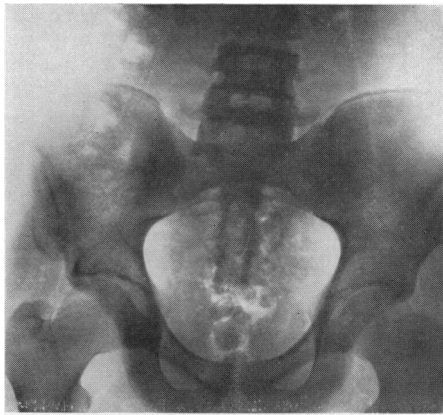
Roentgenogram taken of Case II seven weeks after his injury occurred. The formation callus may be seen.
